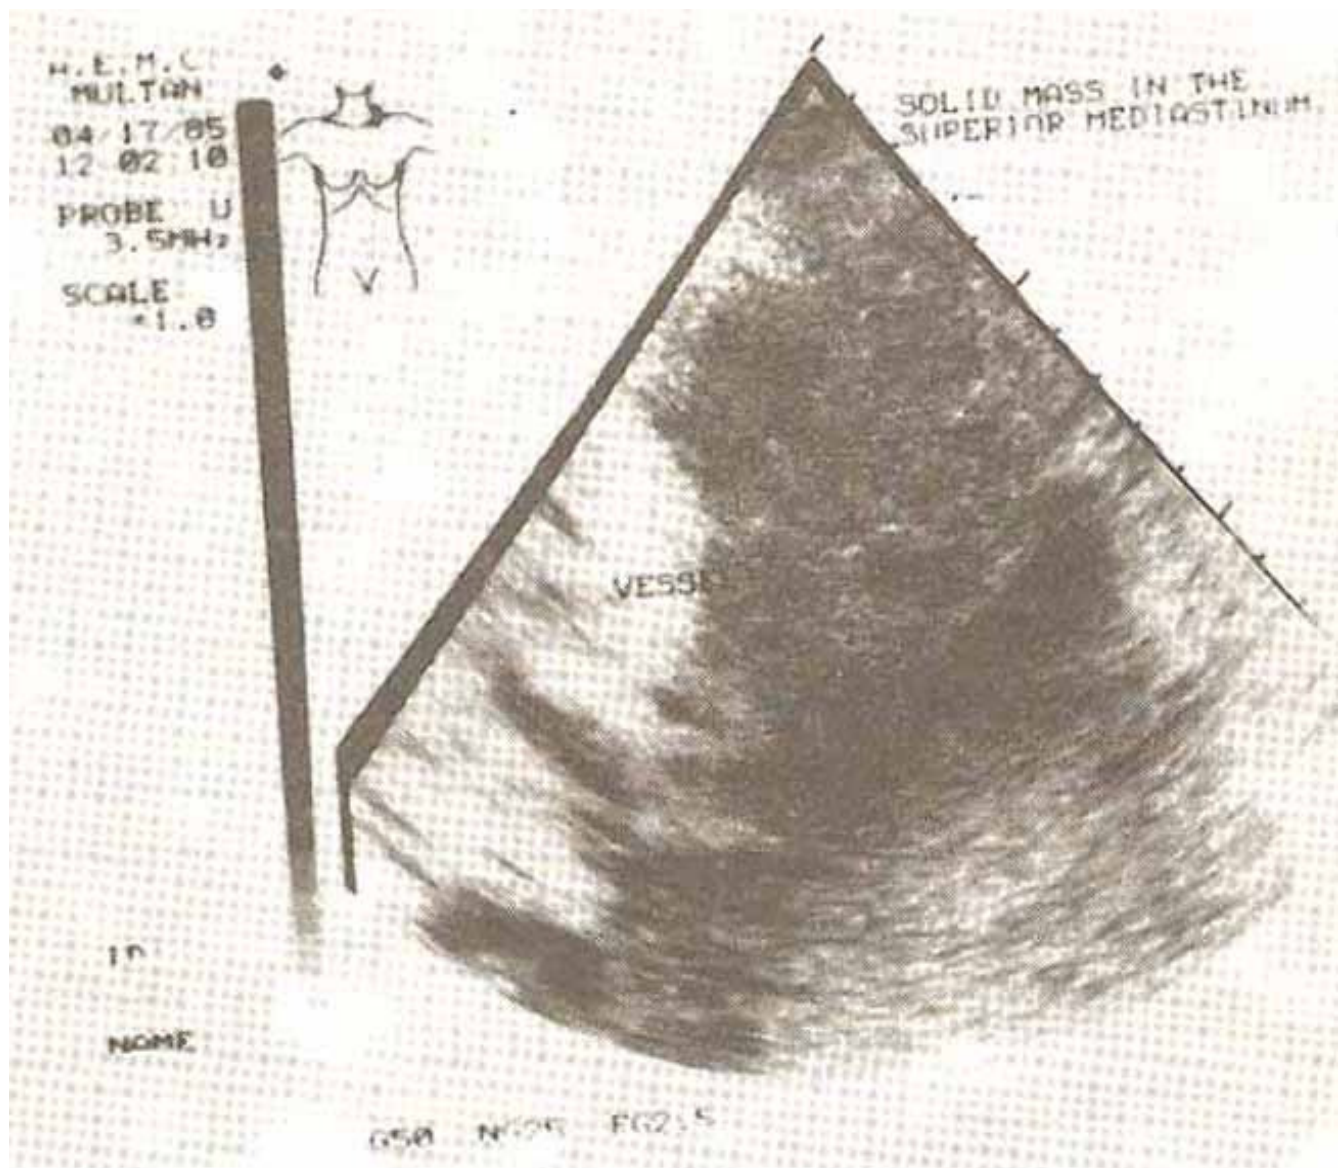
Ultrasound study showing solid mass extending into the mediastinum, continuous with the thyroid echos and with a similar echo pattern, thyroid echos at the top of the picture.
